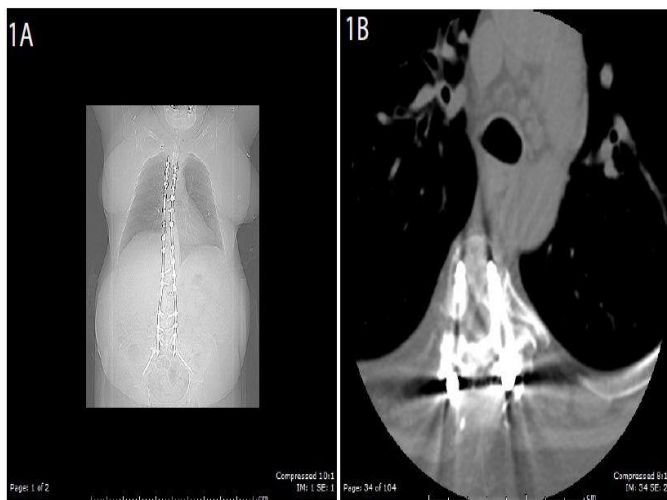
CT thoracic spine (coronal view figure 1a and axial view figure 1b) revealing pedicle screws traversing the disc space at the T3-4 level. Figure 1b reveals the surgical screw causing moderate to severe central stenosis.
